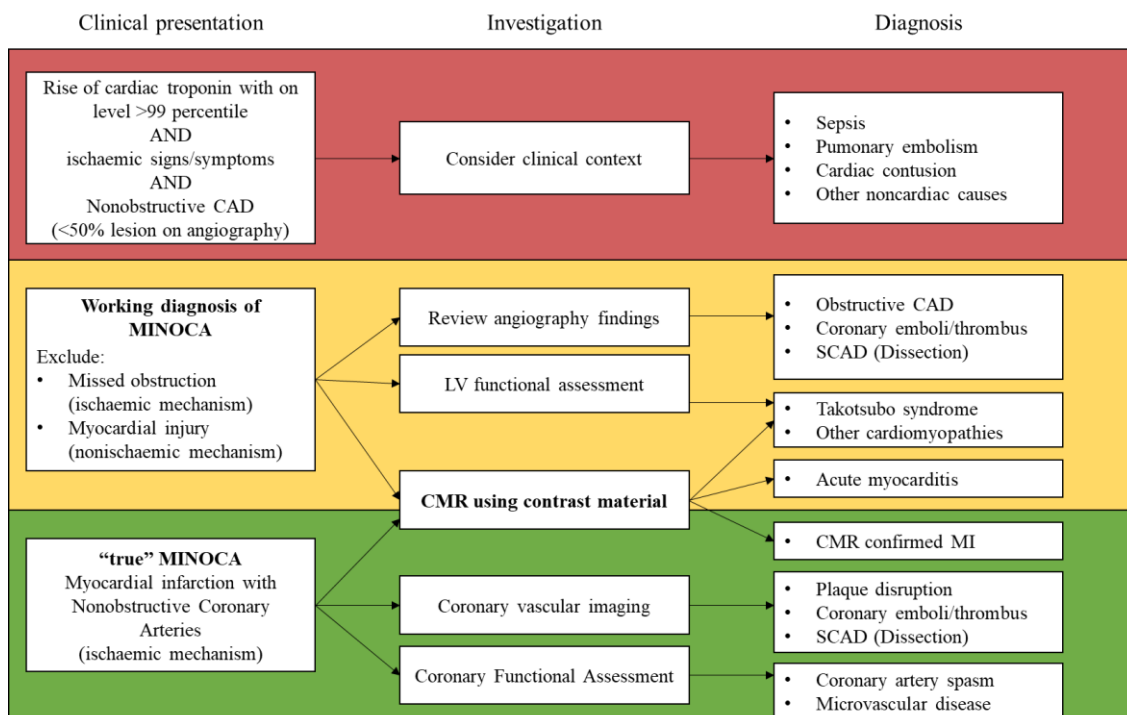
Proposed clinical algorithm for the diagnosis of MINOCA adapted from Tamis-Holland et al (3). Abbreviations: CAD = coronary artery disease, CMR = cardiac magnetic resonance imaging, MINOCA = myocardial infarction with non-obstructed coronary arteries; SCAD = spontan coronary artery dissection
